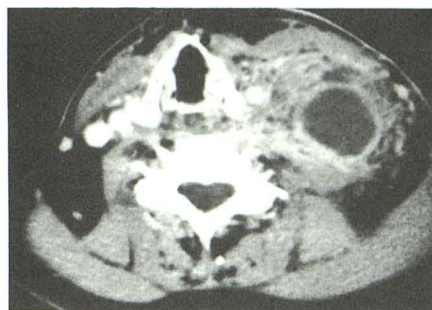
Patient 7. Axial postcontrast CT scan shows thick-walled cystic mass in left neck. Surrounding soft-tissue planes are partially effaced but not infiltrated in the dense manner associated with most tumor spread. Overlying skin and subcutaneous tissues are normal.
